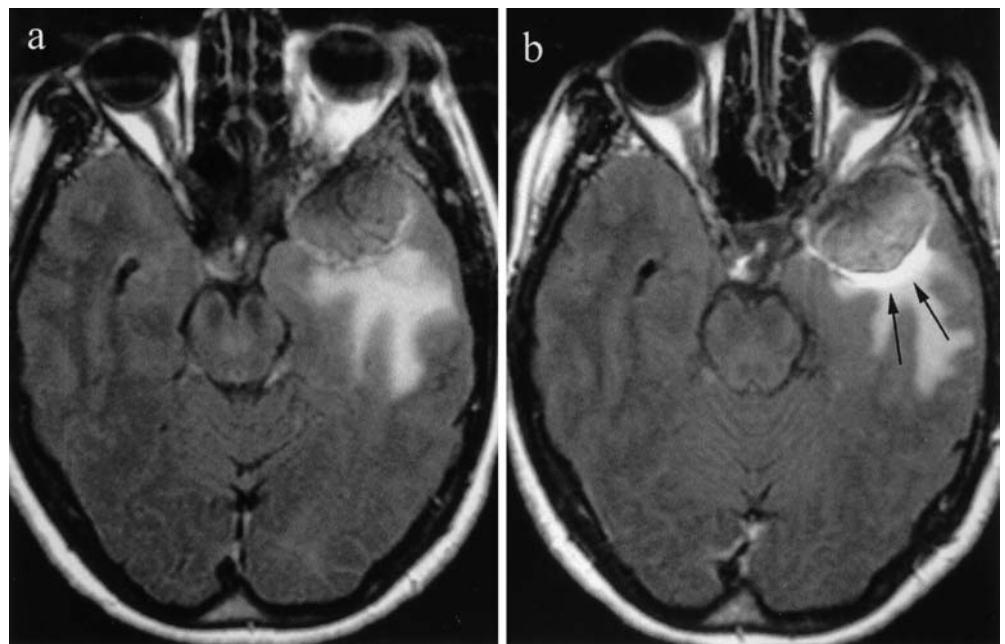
b Strong enhancement of the necrotic component of glioblastoma (*arrows*) associated to gadolinium leakage in the occipital horn of the lateral ventricle (*arrow*). a Precontrast fast-FLAIR sequence
